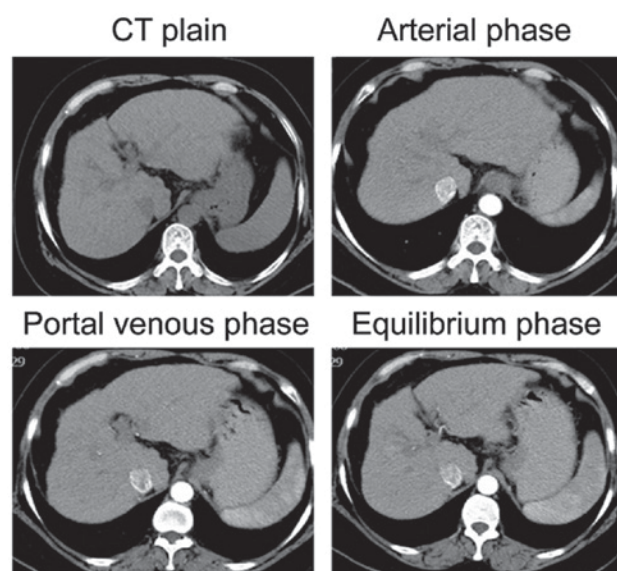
CT plain scan and images in arterial phase, portal venous phase, and equilibrium phase for SHCC patients. CT, computed tomography; SHCC, small hepatocellular carcinoma.
